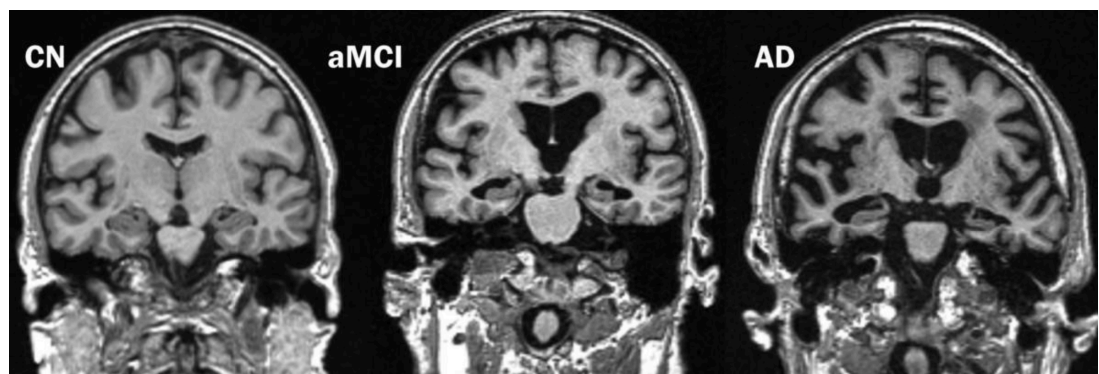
Progressive medial temporal lobe atrophy on MRI in cognitively normal (CN), amnesic mild cognitive impairment (aMCI) and Alzheimer's disease (AD) subjects.
